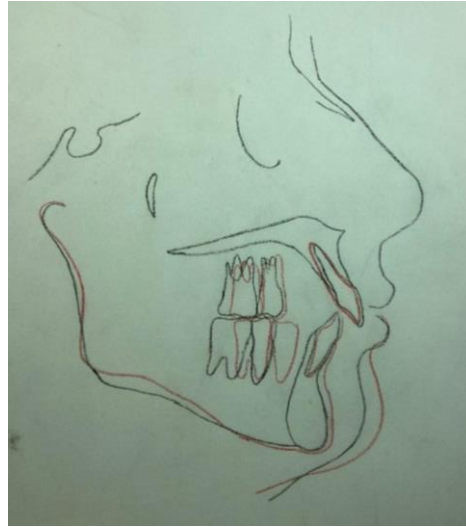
Superimposition of pre and post treatment radiographs
